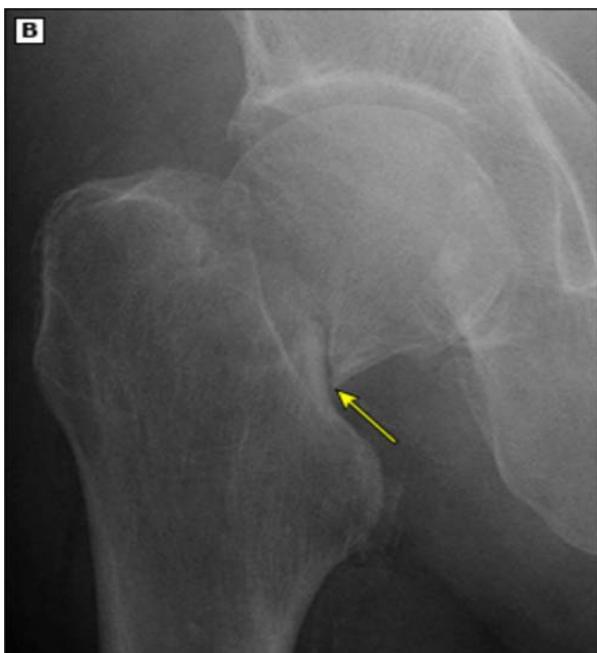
AP x-ray of right femoral neck fracture (displaced)
